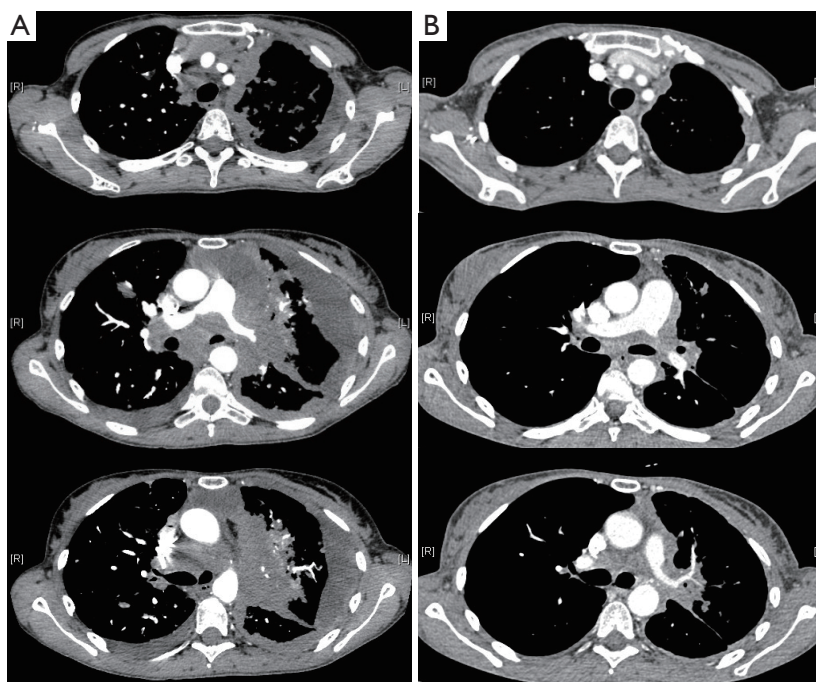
A computerized tomography (CT) scan of the thorax showing an objective response in an ALK-rearranged lung tumor of a patient treated with crizotinib. (A) 49-year-old women, PS 4, with advanced, ALK-traslocated, NSCLC: baseline CT-scan; (B) 49-year-old women, PS 4, with advanced, ALK-traslocated, NSCLC: CT-scan two weeks after treatment initiation with crizotinib.
